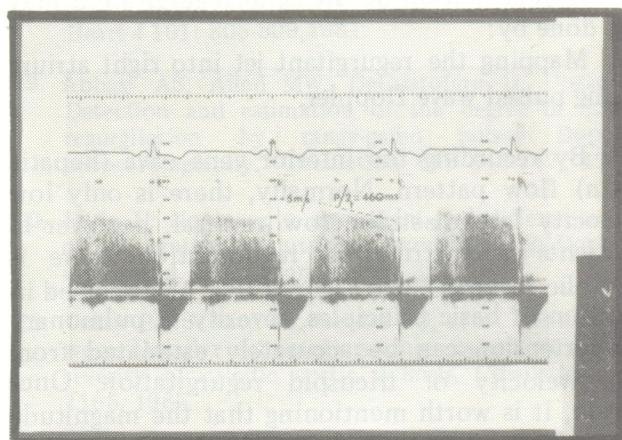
Continuous wave Doppler study across the aortic valve recorded from the apex. It shown a high velocity (4.8 m/sec) regurgitant jet with a pressure halftime (P/2t) of 460 milliseconds suggestive of mild aortic regurgitation.
